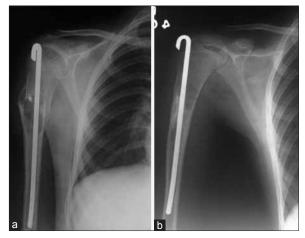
X-ray anteroposterior view of (R) arm with shoulder joint showing pathological fracture in a case of aneurysmal bone cyst humerus treated with curettage only; stabilised with rush nail (a), eventually healed well showing good remodelling at 3 years (b)
